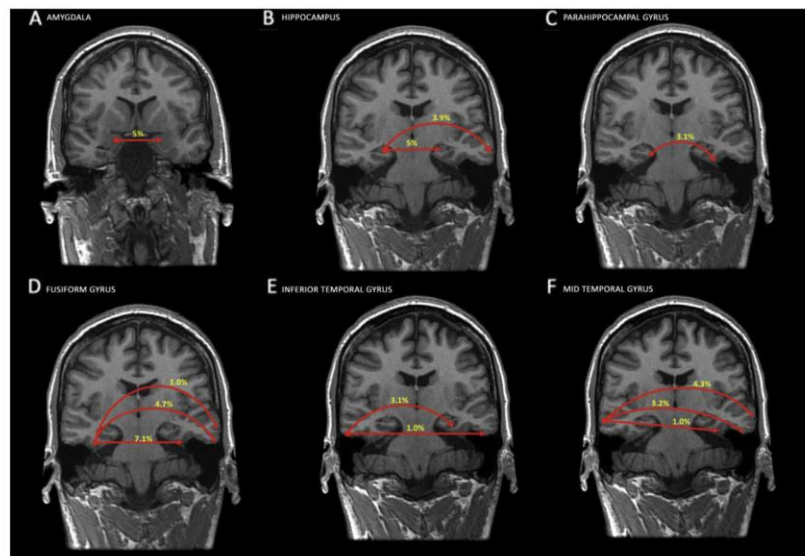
Coronal MRI showing void flows from the stimulation site to all identified contralateral temporal responses. The stimulated site is shown next to panel letter. The percentages of hemispheres presenting each projection are shown in yellow. Arrows go from stimulated site to the regions showing responses. Data from all hemispheres from all patients are pooled together as going from right to left. A) Contralateral projections from the amygdala. B) Contralateral projections from the hippocampus. C) Contralateral projections from the parahippocampal gyrus. D) Contralateral projections from fusiform gyrus. E) Contralateral projections from the inferior temporal gyrus. F) Contralateral projections from the mid temporal gyrus.
